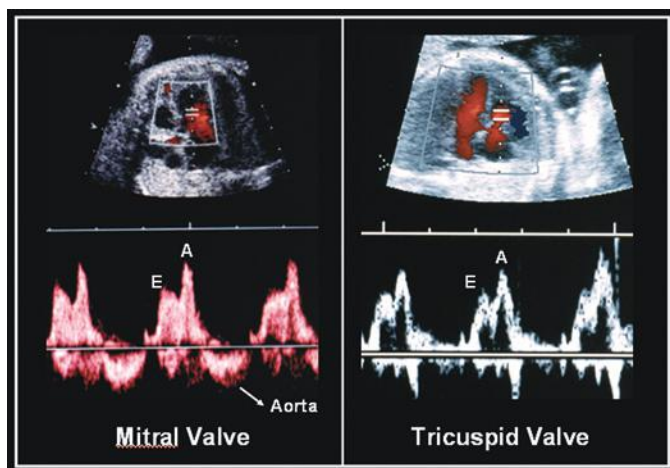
Doppler waveforms obtained across the mitral and tricuspid valves. Owing to the proximity of the mitral and aortic valves, a portion of the aortic outflow is noted during systole (arrow, aorta). A, A wave; E, E wave.
